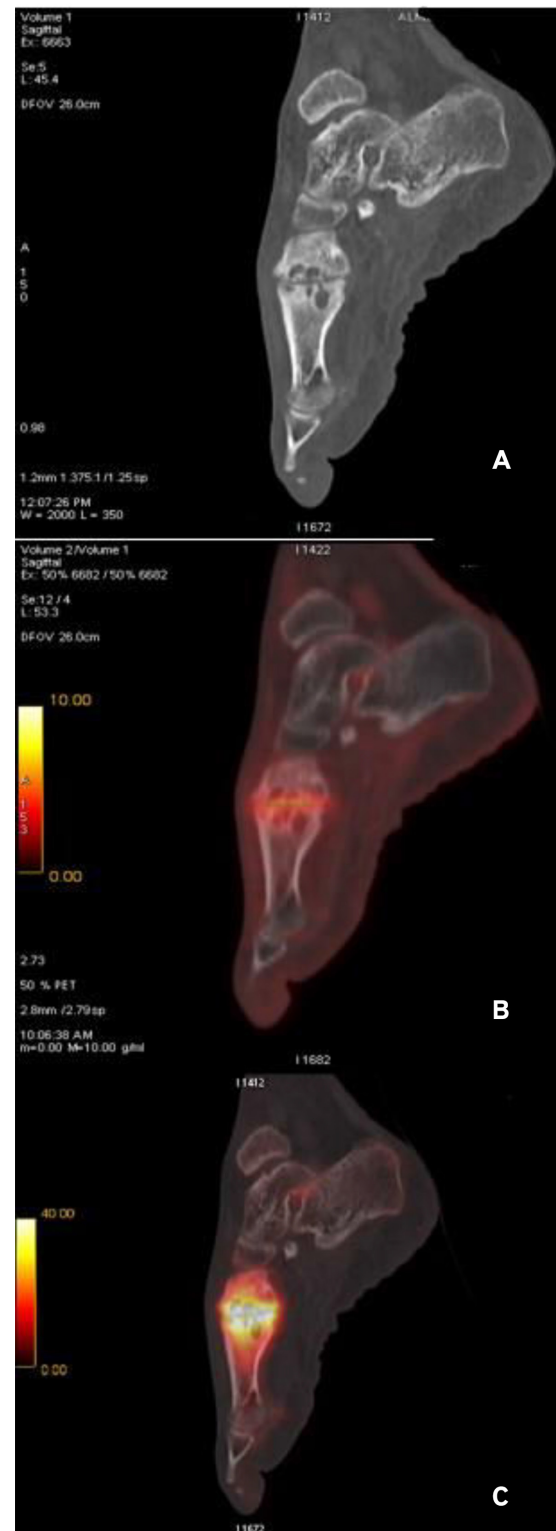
A) Image represents sagittal CT scan demonstrating subchondral bone cysts at the left cuneiform bone and the base of the first metatarsal bone. B) F18-FDG PET/CT section represented in the middle image which shows increased flow to the left first tarsometatarsal joint. C) The image represents the fused NaF PET/CT scan of the left foot, revealing increased osteoblastic activity in the first tarsometatarsal joint.
